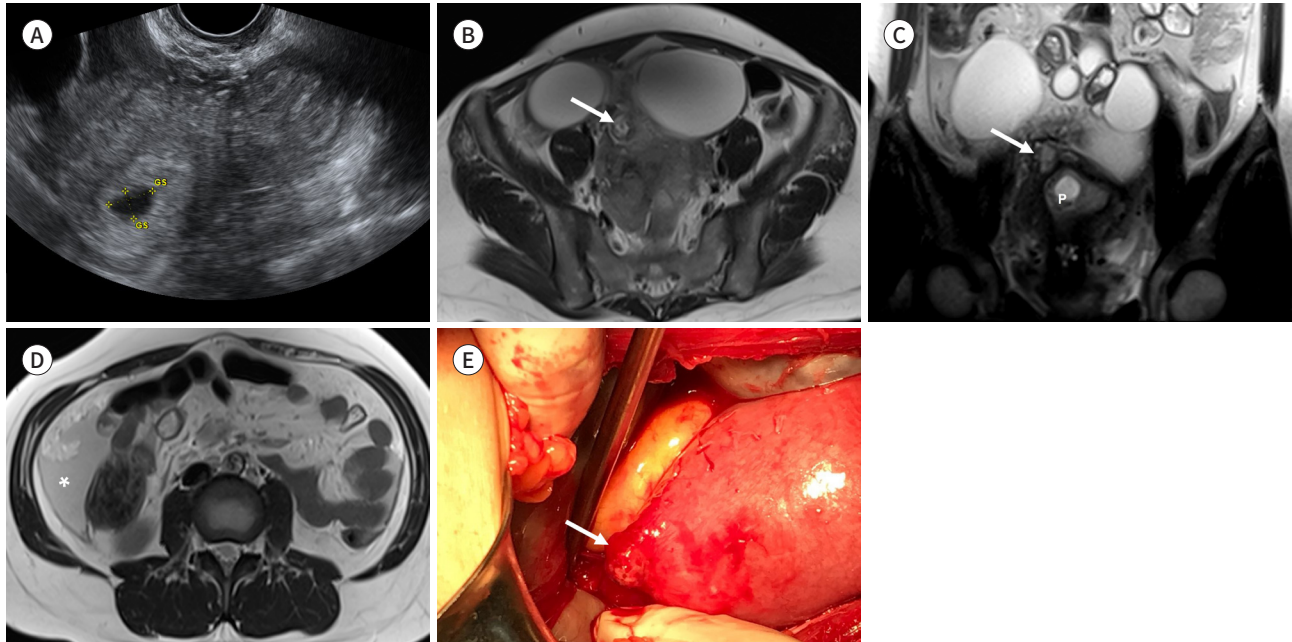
MR imaging findings in a 27-year-old woman with right lower quadrant pain for 1 day.
